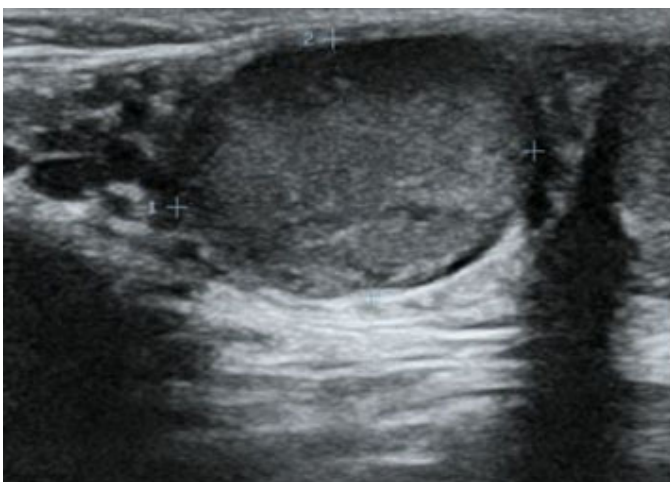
Ultrasonography showed homogeneous hyperechoic lesion measuring approximately 2 cm.
